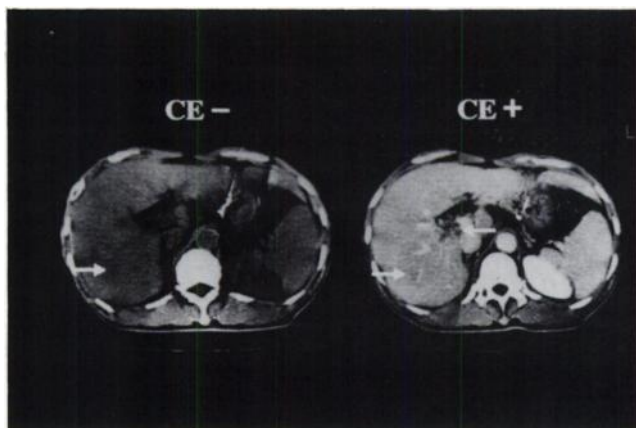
Data from a 63-yr-old male patient (Patient 10) with diffuse HCC. The diffuse HCC lesion remains poorly differentiated on either plain (CE -) or contrast enhancement (CE +) CT (←). A small defect of the tumor thrombus in the portal vein is evident on contrast enhancement CT (←).
